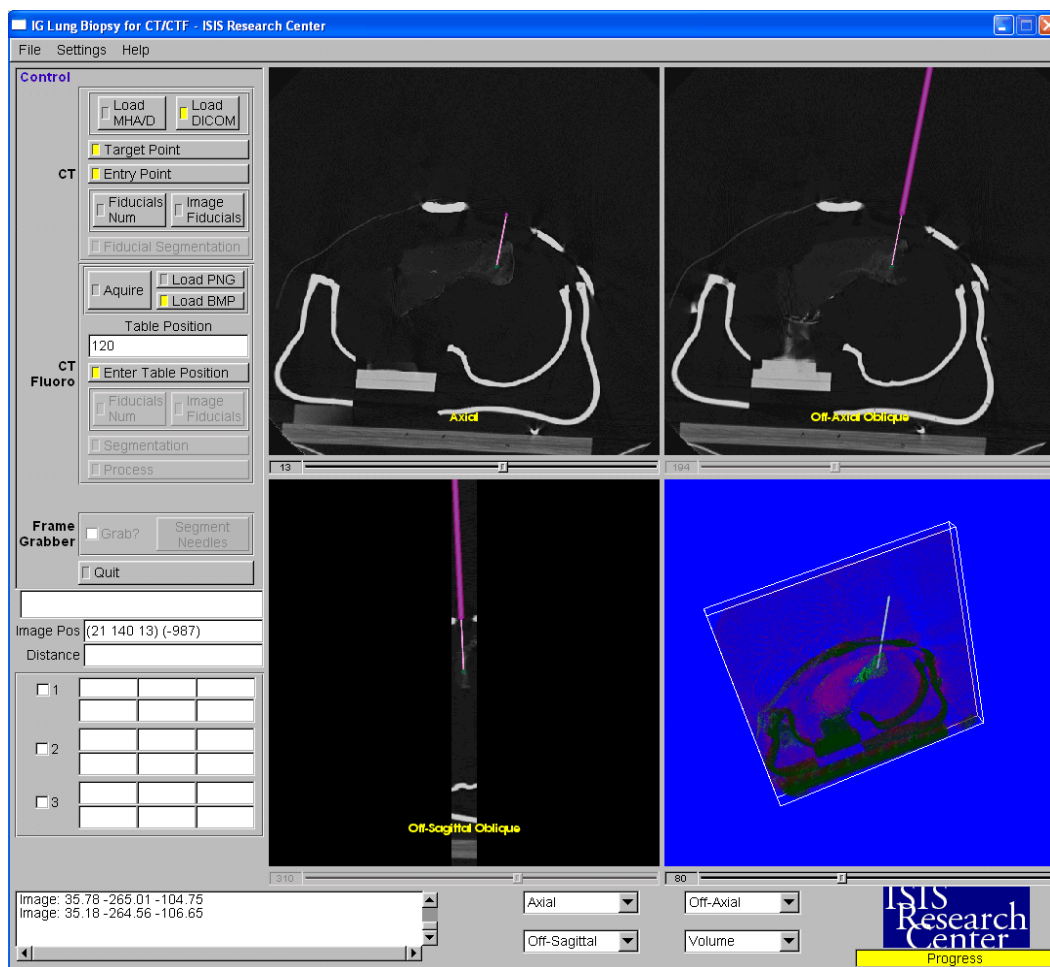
Biopsy software for targeting lesions using CT fluoroscopy
